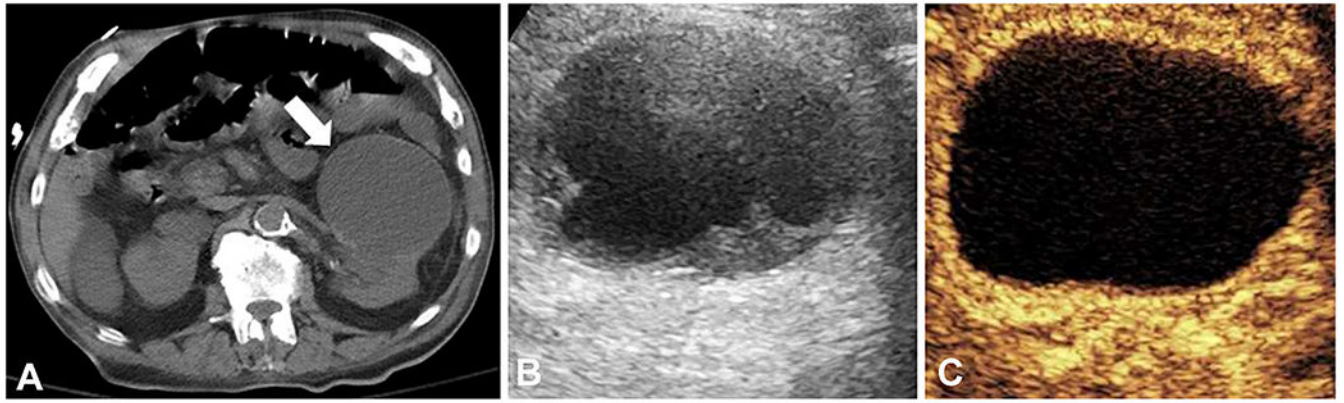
Indeterminate renal lesion better characterized by contrast-enhanced ultrasound. (A) Non-contrast CT demonstrating a $7.4 \times 4.2 \times 8.6$ cm exophytic left renal mass (arrow). (B) Gray-scale ultrasound demonstrating a $7.1 \times 7.0 \times 6.2$ complex hypoechoic cystic lesion with septations. (C) Contrast-enhanced ultrasound demonstrating a $7.1 \times 7.0 \times 6.2$ complex cystic lesion with no internal enhancement consistent with a benign or indolent lesion.
